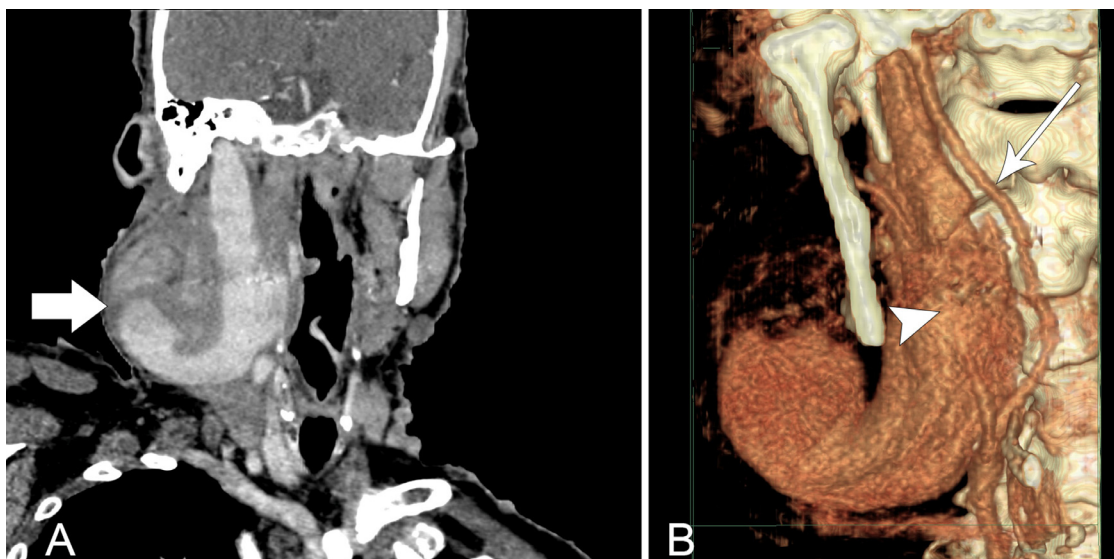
Contrast enhanced CT neck, (A) coronal view showing the large right internal jugular vein aneurysm (arrow) showing contrast enhancement. (B) 3D reformats anterior projection showing the extent of the aneurysm and its relationship with the ectatic internal jugular vein (arrowhead). Note the normal right internal carotid artery (long arrow).
